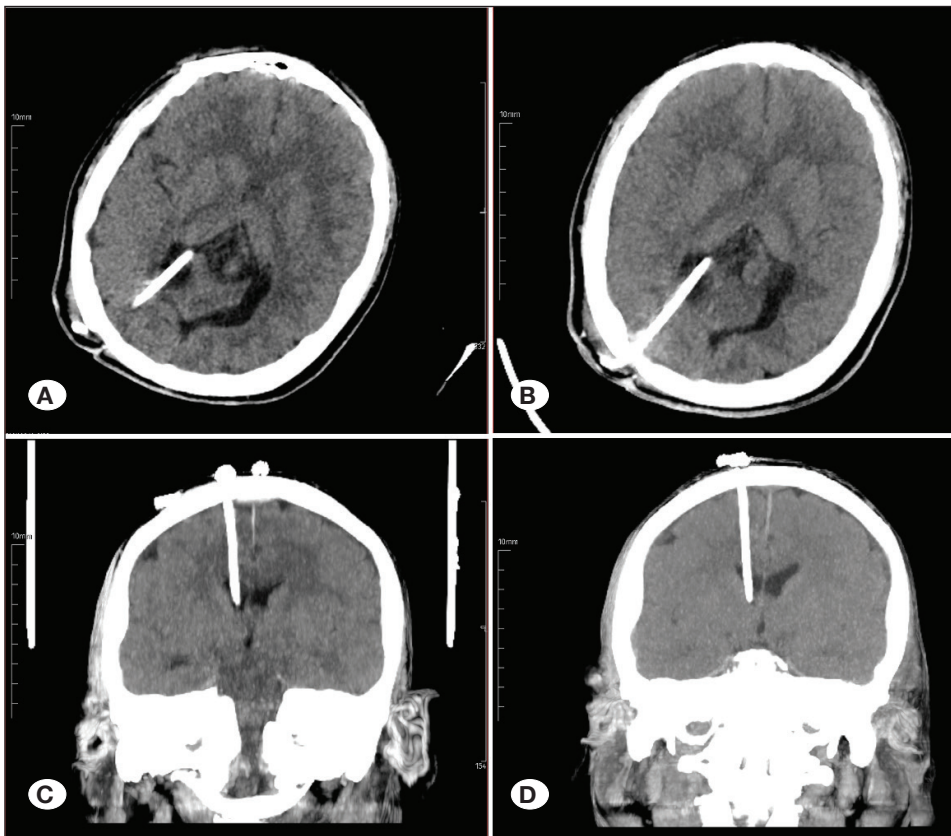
Computed tomography (CT) images of two different revision cases. A) Preoperative and B) postoperative axial images of Patient 1. C) Preoperative and D) postoperative coronal images of Patient 2.
